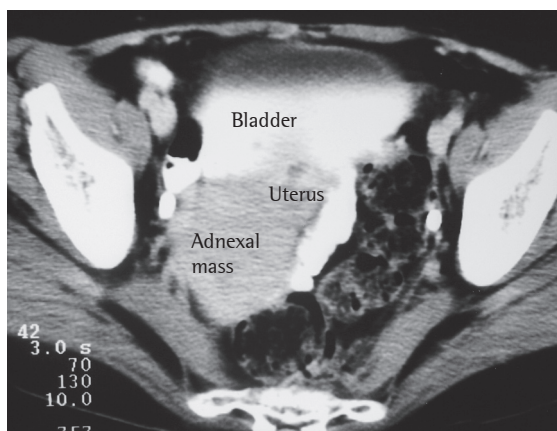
Computed tomography slice of the pelvis shows a discretely heterogeneous mass in the right ovary, located next to the uterus.
